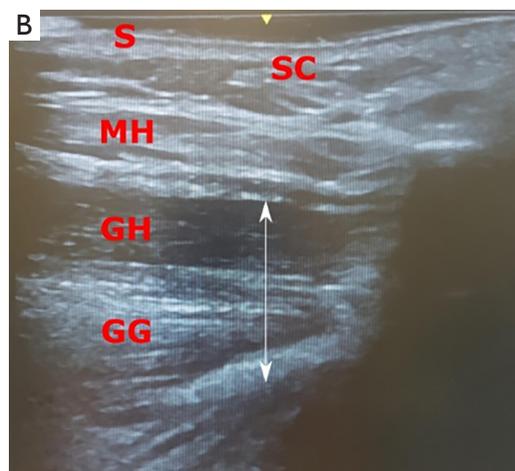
Sagittal view. (A) the position of the transducer in the submental area (mid-sagittal plane), (B) ultrasound scan in the mid-sagittal plane with the following structures: skin (S), subcutaneous tissue (SC), mylohyoid (MH), geniohyoid (GH) and genioglossus (GG). The distance of the upper margin of GH to the lower margin of GG represents the tongue base thickness (white arrow).
